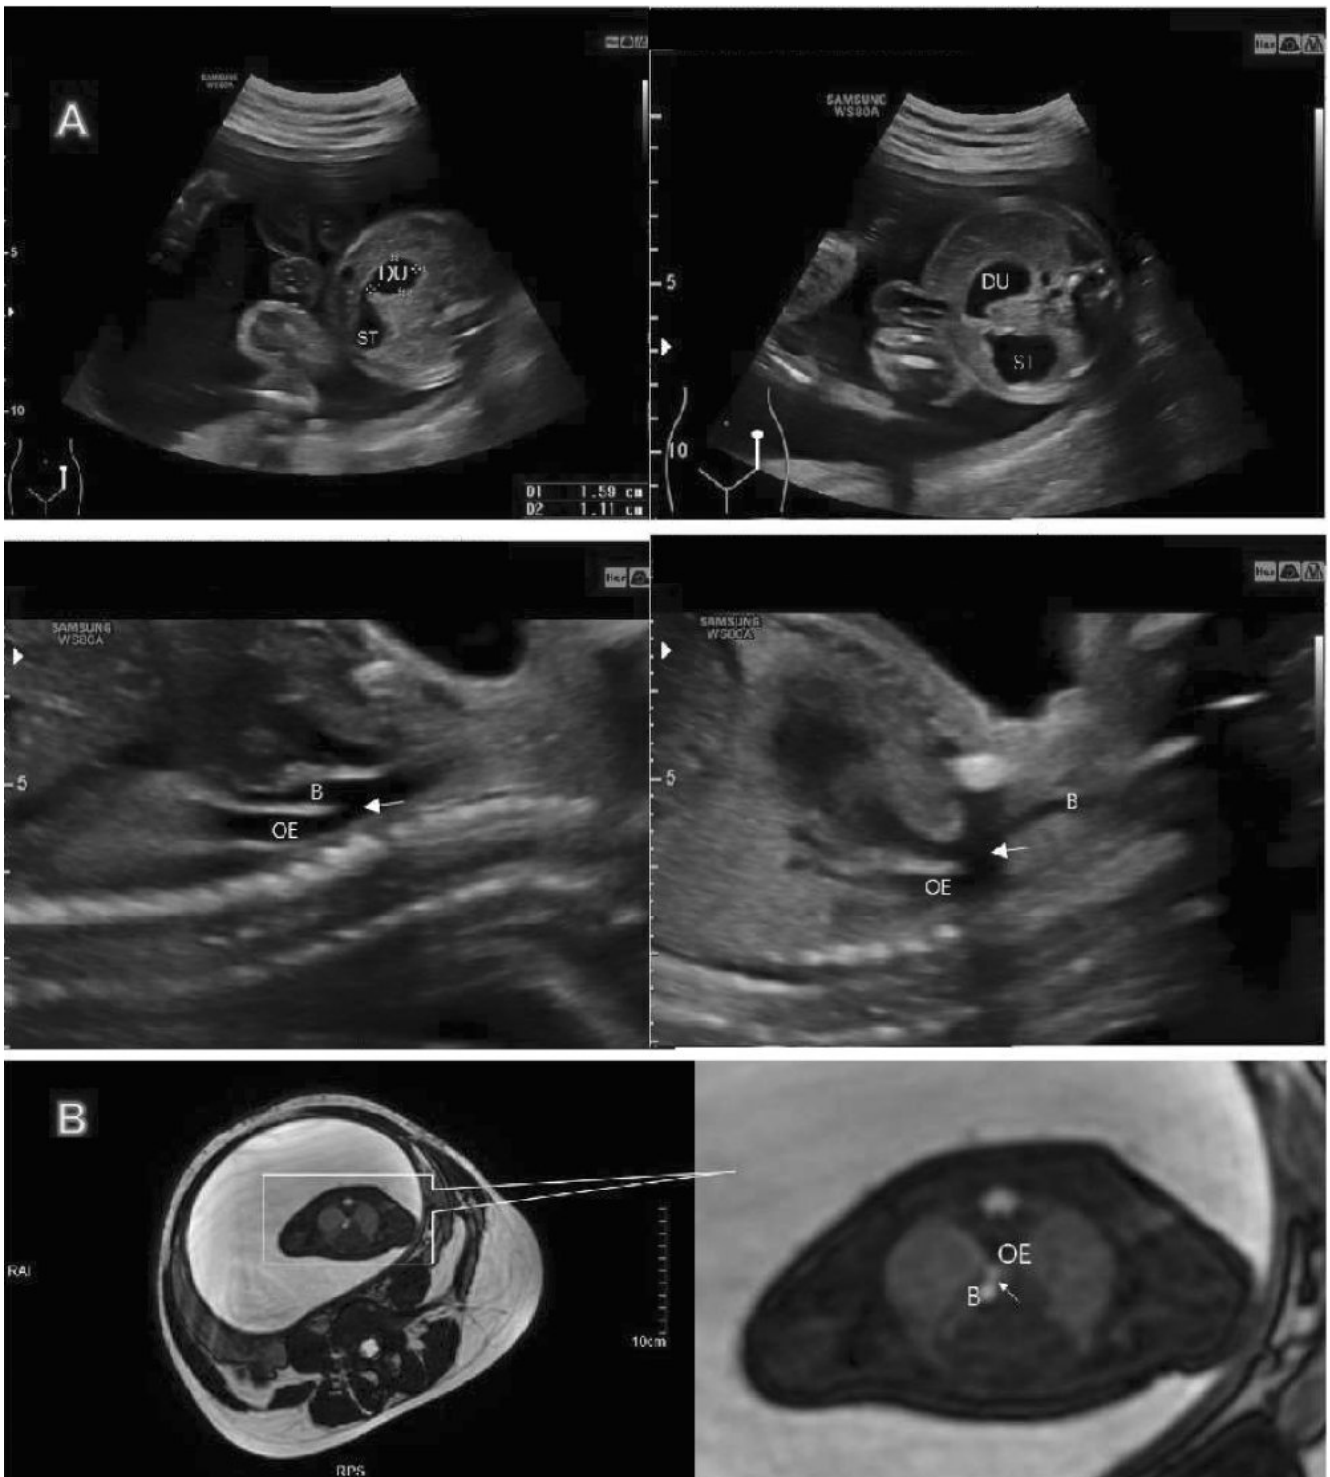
Prenatal ultrasound and magnetic resonance imaging. (A) Ultrasound showed findings of tracheoesophageal fistula and suggestive bilateral bronchial atresia (DU: duodenum; ST: stomach; B: bronchus; OE: esophagus; White arrow: tracheoesophageal fistula). (B) Magnetic resonance imaging showed findings of tracheoesophageal fistula (B: bronchus; OE: esophagus).
